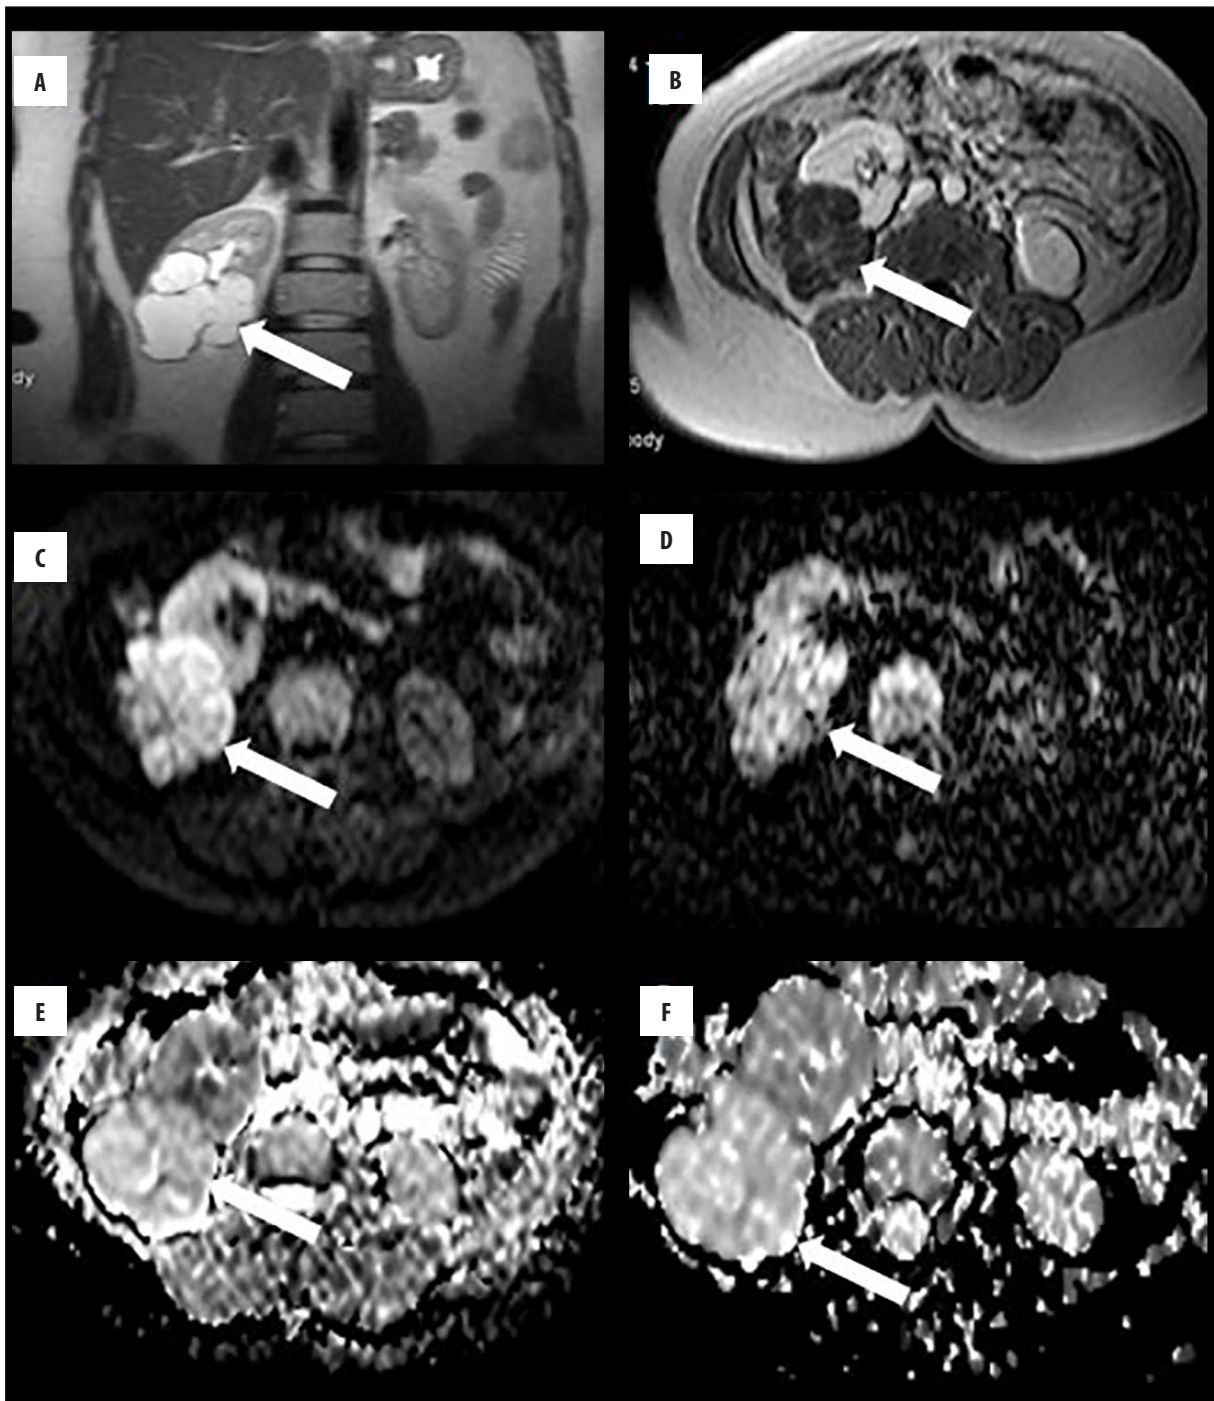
A 66-year-old man with transitional cell carcinoma in the right kidney. (A) T2-weighted axial image shows an isointense right renal pelvic mass. (B) Gadolinium-enhanced fat-suppressed T1-weighted magnetic resonance image demonstrates enhanced right renal pelvic mass. (C, D) Axial diffusion-weighted images with b values of 600 and 1000 s/mm<sup>2</sup> show markedly high signal intensity. (E, F) The apparent diffusion coefficients are  $1.3 \times 10^{-3}$  and  $1.03 \times 10^{-3}$  mm<sup>2</sup>/s at b=600 and 1000 s/mm<sup>2</sup>, respectively.
